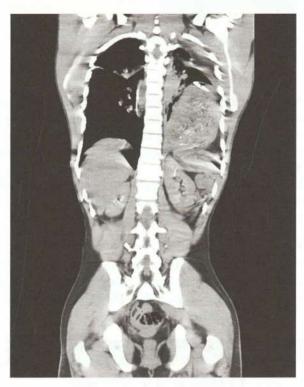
Diaphragmatic hernia—CT scan (*Courtesy:* Dr Yashdeep Sharma, Associate Professor, KMC, Manipal)
